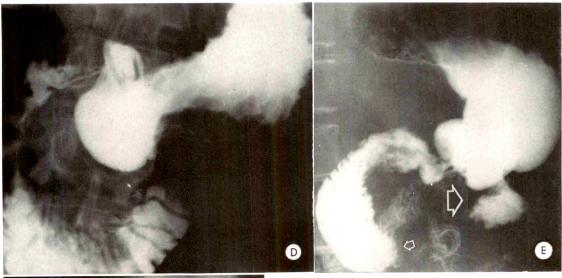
(C) Mass in the body of the pancreas flattens the anterior border of fourth portion of duodenum. (D) Same patient. Slight oblique spot roentgenogram better demonstrates the impression. (E) Mass in the body of the pancreas impressing the duodenojejunal junction.
